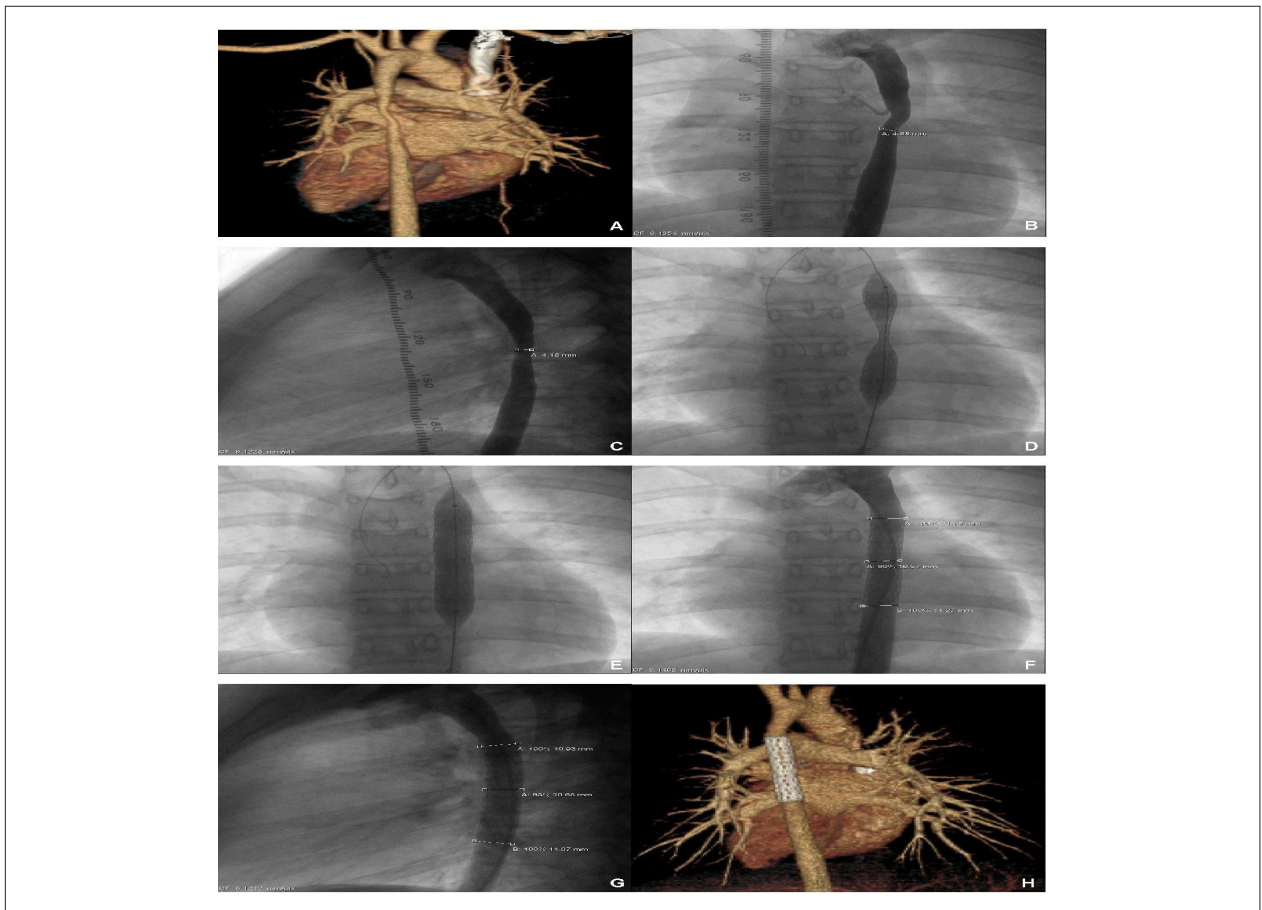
Computed tomography (1A), frontal thoracic aortography (1B), and lateral thoracic aortography (1C) showed an isolated long-segment mid-thoracic aortic coarctation. A dumbbell morphology (1D) was visualized before full expansion of an Advanta V12 Large Diameter Stent (AVLDS). After implantation, repeated thoracic aortography (1E) showed full AVLDS dilatation. Follow-up thoracic aortography (1F and 1G) and computed tomography (1H) showed in situ AVLDS anchoring to the aortic wall effectively and covering the full length of the coarctation sufficiently.
